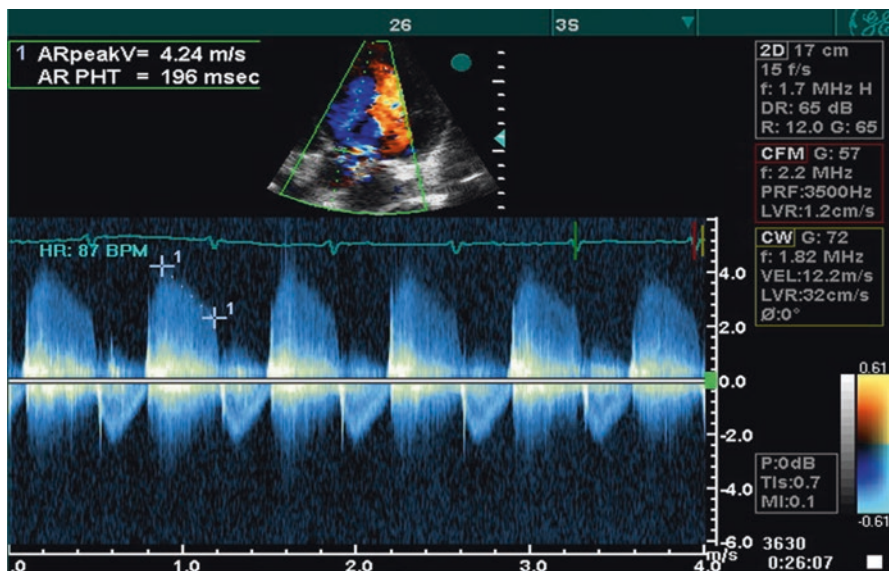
Color-Doppler flow of Severe AI, AI flow PHT = 196 ms
